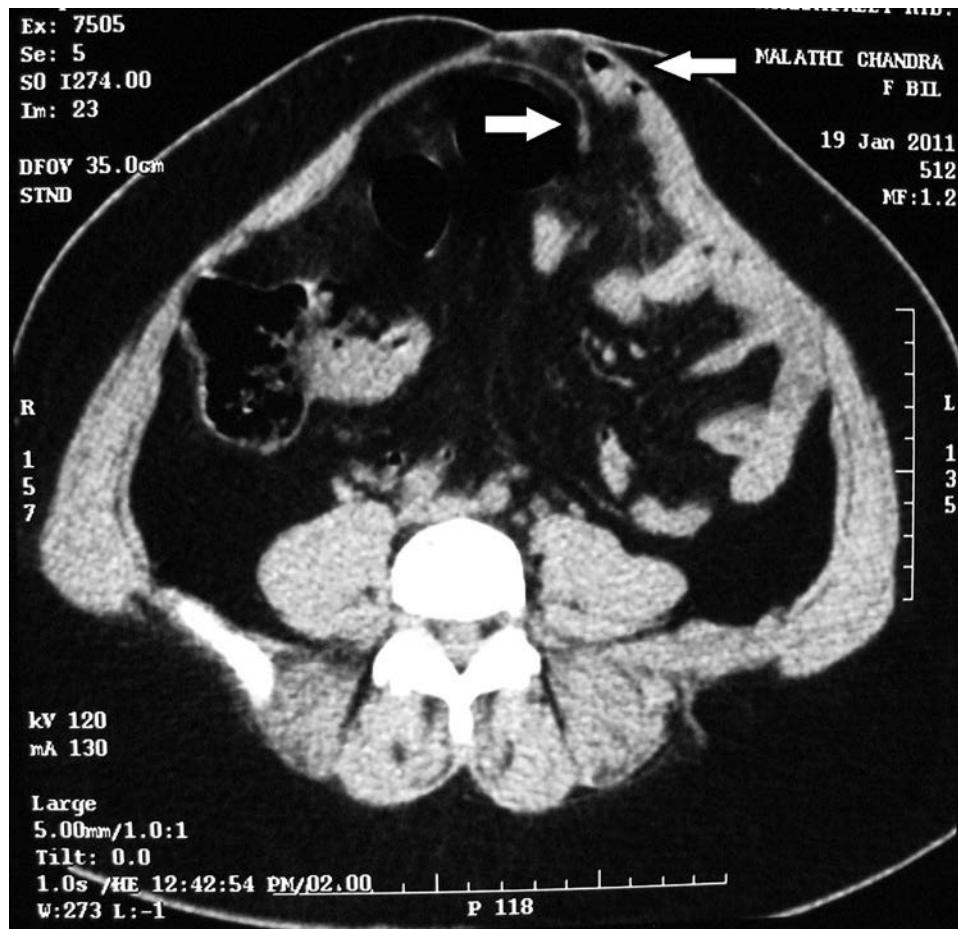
Coronal view of computed tomography scan showing herniated bowel with omentum (top arrow) and separated edge of mesh (bottom arrow).
